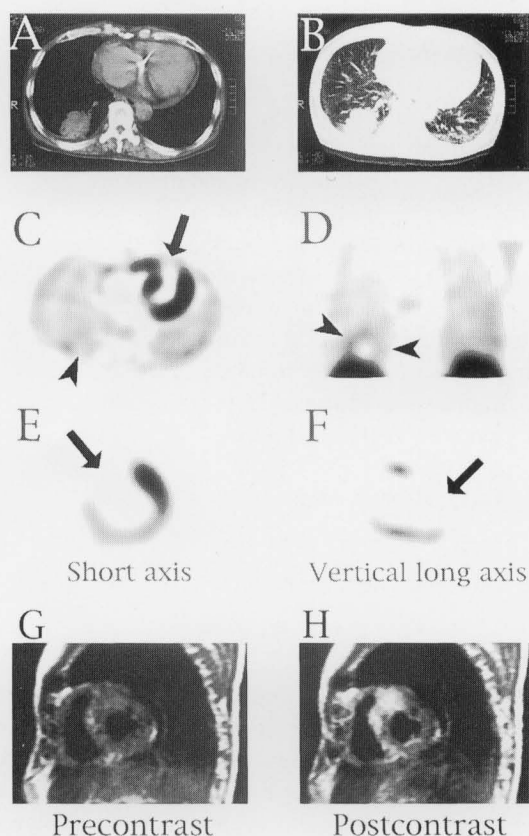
(A and B) Thoracic CT showed a mass lesion in the lower lobe of the right lung and pericardial effusion. (C, D, E and F) Tc-99m-MIBI SPECT showed a photon deficient area in the anteroseptum (arrows) and an abnormal accumulation corresponding to the periphery of the right lung mass lesion (arrowheads). (G and H) T1-weighted MR images showed an enhancement with contrast medium in the anteroseptum.
